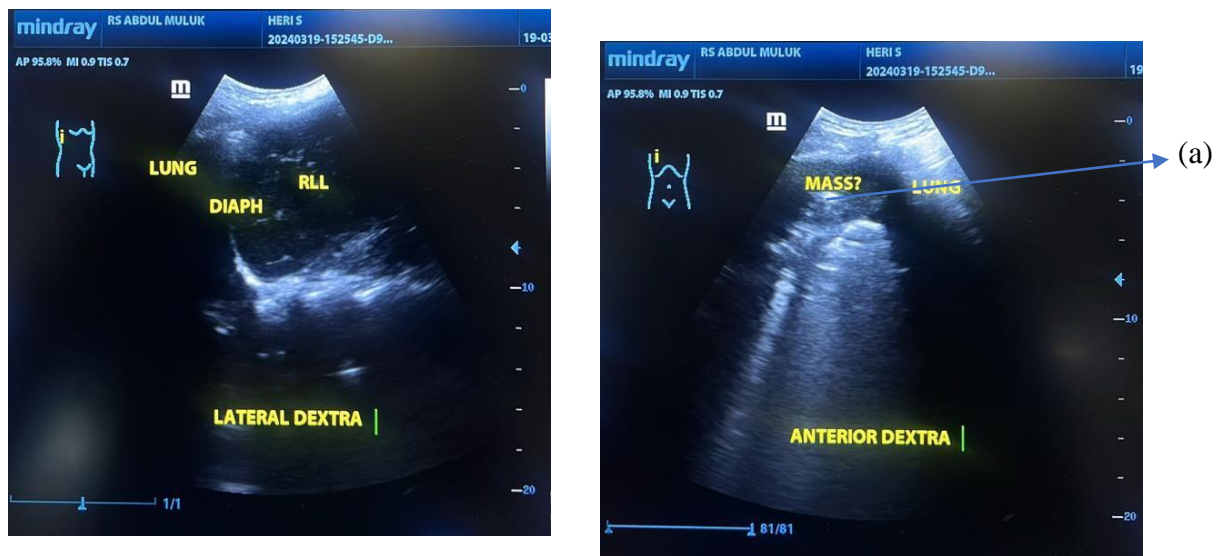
An Ultrasonography examination, (a) a tumor on the anterior dextra lung
